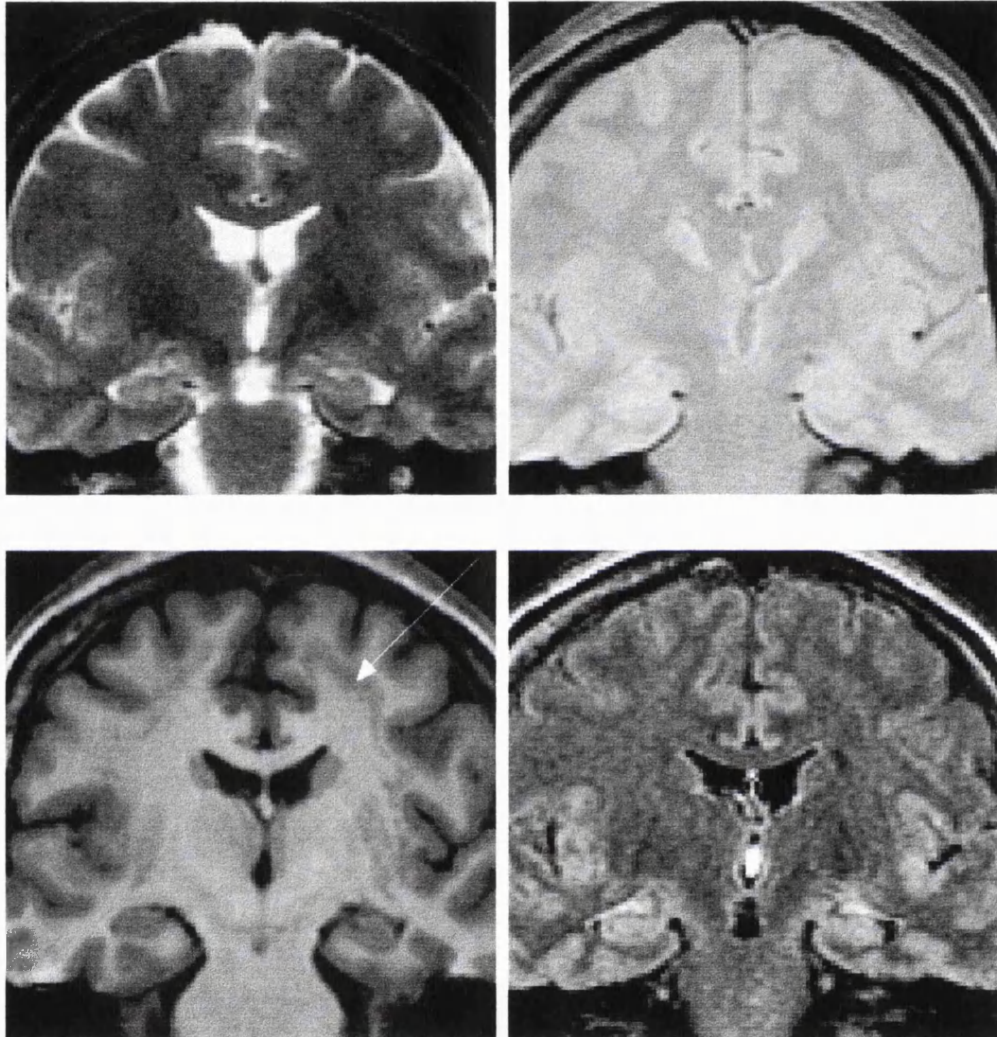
BAND HETEROTOPIA. Coronal spin echo T2-weighted image (top left), proton density weighted image (top right), T1-weighted image (bottom left) and fast FLAIR image (bottom right). A band of ectopic grey matter underlying the cortex (“double cortex”) is shown (arrow). The abnormality is bilateral and fairly symmetric. The heterotopic grey matter is most conspicuous on the T1-weighted image and could be overlooked on fast FLAIR. The patient had partial epilepsy.
